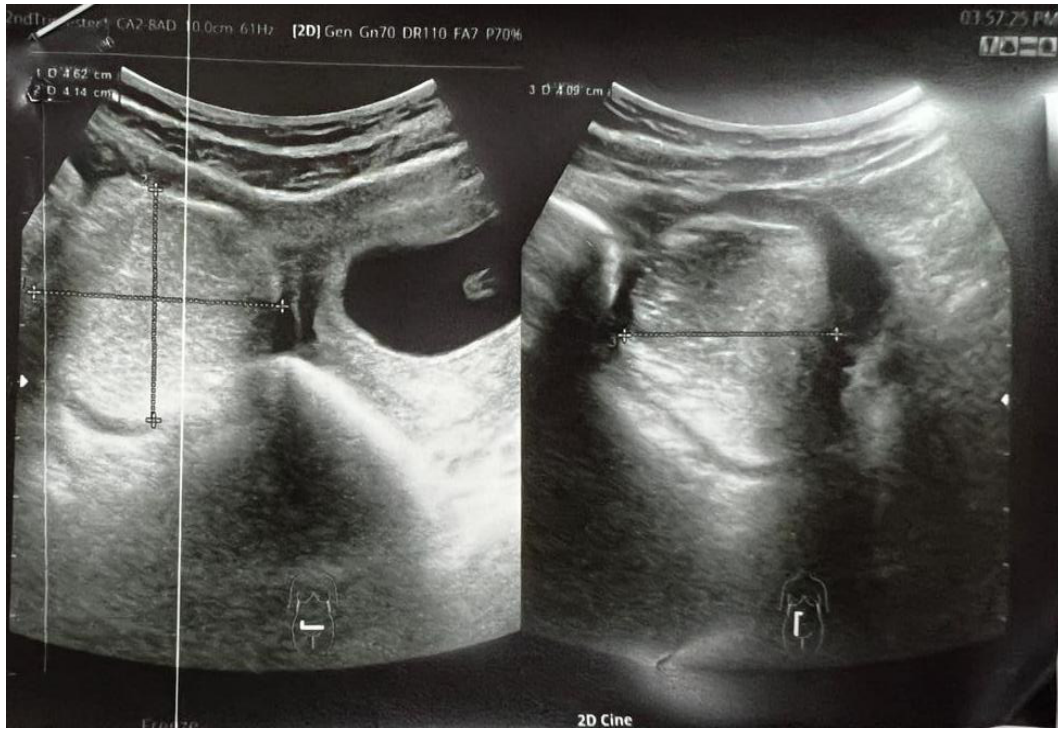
Ultrasound picture at 8 weeks gestation showed one large heterogenous echogenicity cystic mass size of 4.6 cm x 4.1 cm
